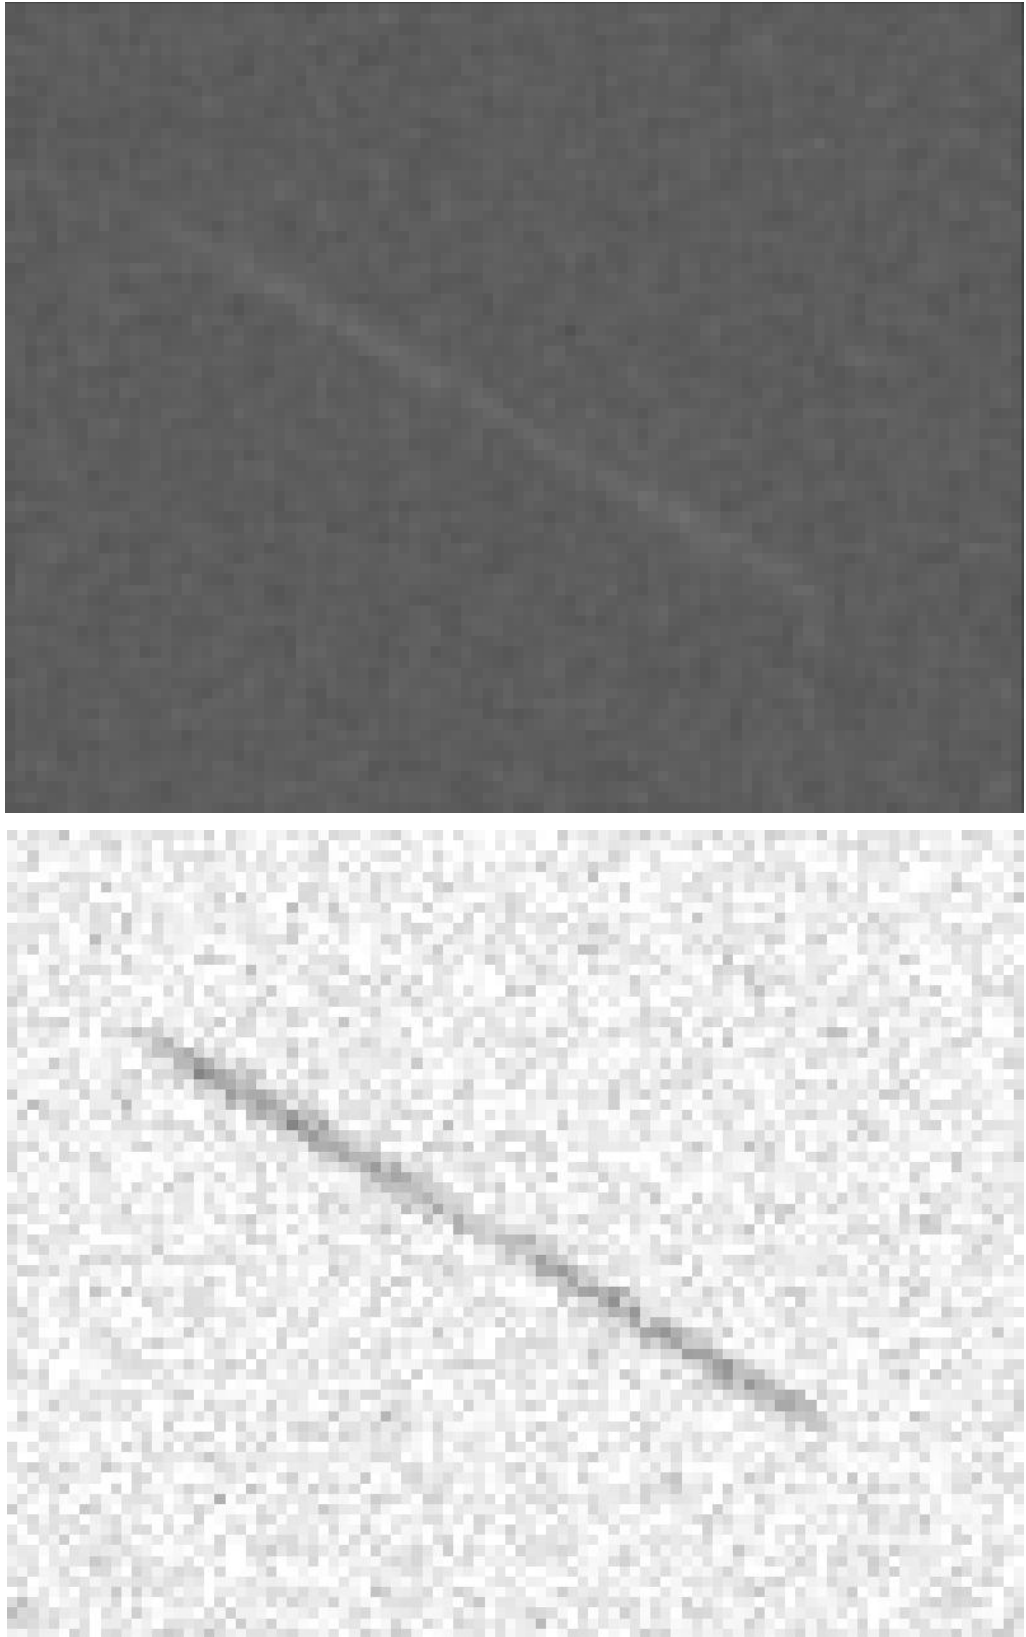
Blurred and noise-added artificial (top) CT and (bottom) MR images
